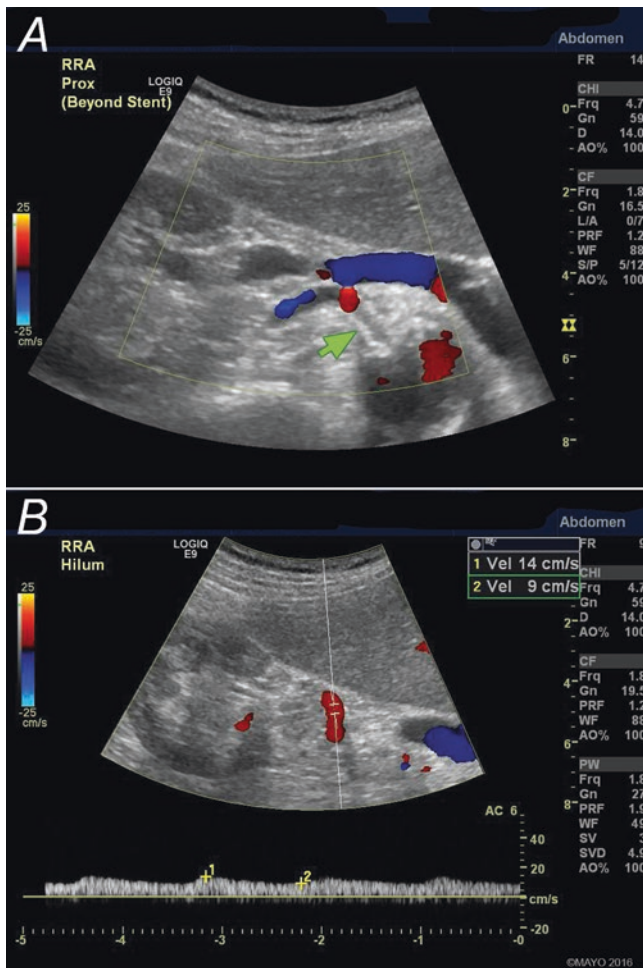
Color Doppler ultrasound of an occluded renal artery stent. Color Doppler demonstrates the absence of flow within a well depicted renal artery stent (a, arrow). Color flow is demonstrated in the distal renal artery with low velocity and a tardus parvus waveform (b) which are secondary findings associated with a proximal occlusion. By permission of Mayo Foundation for Medical Education and Research. All rights reserved
